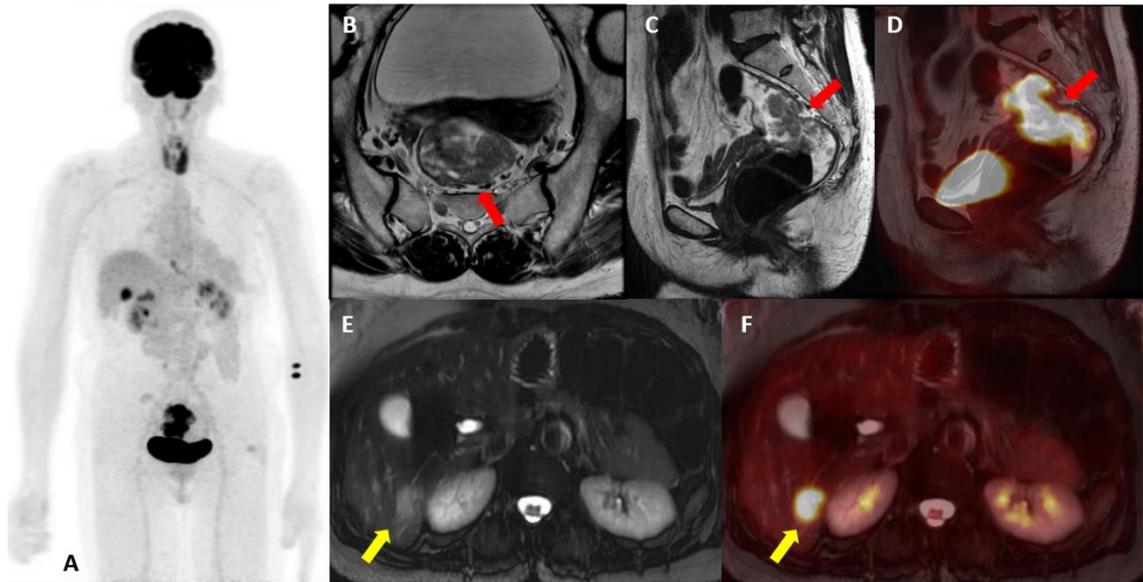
Sixty-three-year-old woman with liver metastasis. Coronal MIP PET (A), axial T2w (B, E), sagittal T2w (C), and fused PET/MR (D, F). On pelvic MR, the primary rectal tumor (red arrows) was characterized as low-risk, presenting as mrT2N0 without mesorectal fascia involvement or extramural vascular invasion. On FDG-PET/MR, however, the primary tumor (white short arrows) presented high-risk values for MTV and TLG (60.8 and 463.5, respectively) and the patient presented a metastatic lesion in the liver on the DWI and fused PET/MR (white arrowheads). (MR - Magnetic Resonance, FDG - fluorodeoxyglucose, PET/MR - Positron Emission Tomography/Magnetic Resonance, MTV - Metabolic tumor volume and TLG - Total lesion glycolysis, DWI - diffusion weighted-imaging)
